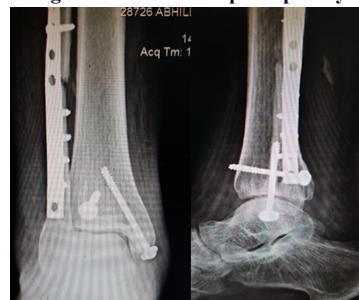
6 month post op xray showing union
